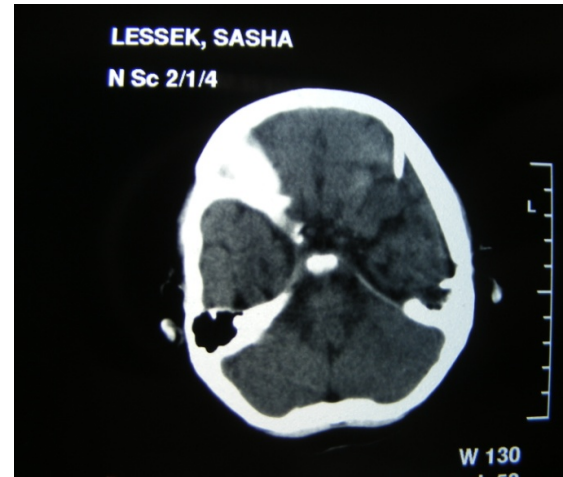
CT scan postoperative aspect of the same cyst as figure 5 after cysto-peritoneal shunting, and the patient
